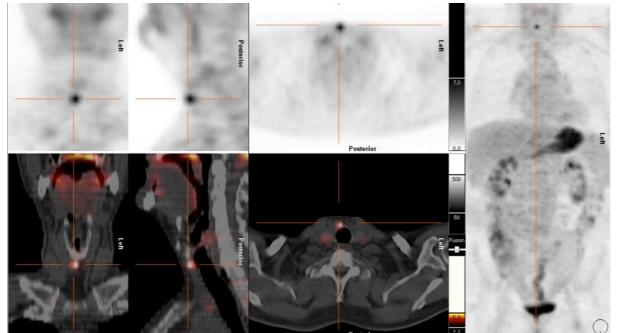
Example of a FDG-PET/CT positive thyroid nodule in the isthmus, which proved to be a 10 mm differentiated papillary thyroid carcinoma (pT1a cN0M0)
